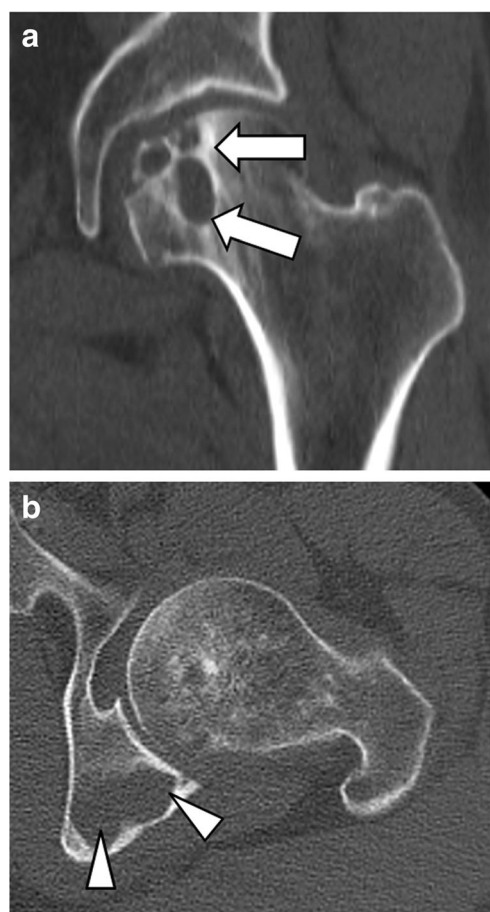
Reformatted a coronal and b transverse. CT images show osteolytic lesions within the left femoral head (*arrows* in a), presenting a multilocular appearance and peripheral sclerosis, and a more homogeneous osteolytic appearance within the left ilio-ischiatic branch (*arrowheads* in b)
